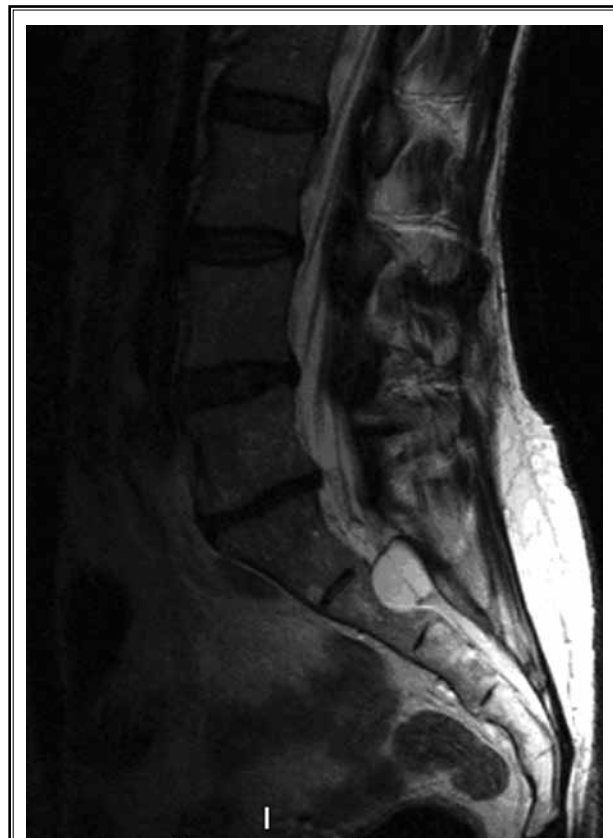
Sagittal T2 MRI demonstrating large hyperintense TC at S2 with evidence of significant laminar erosion. Also seen is loss of disc height at L5/S1.
